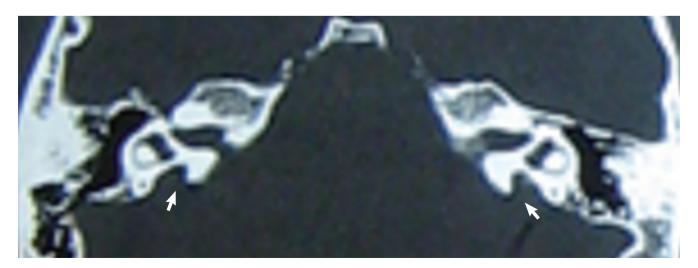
Computed tomography scan of the temporal bone for patient IV-8 (from family Iranian 3) with bilateral enlarged vestibular aqueduct.
